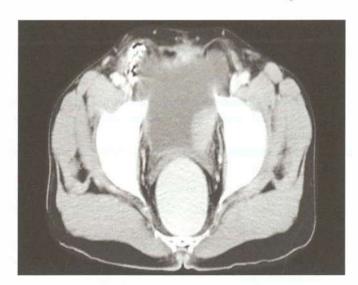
CT scan showing bladder carcinoma
